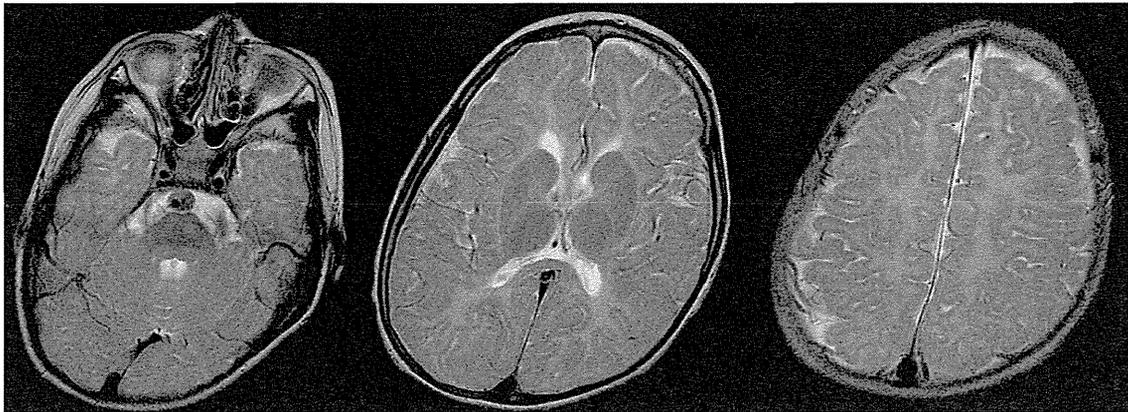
(Case 14, Type B). This patient was a 13-year-old male with *PLP1* duplication, and the clinical stage was F3. His symptoms started at birth with nystagmus, hypotonia, spasticity, and pyramidal signs. The first MRI was performed at 6 years old. The myelination age was 0–4 months on T1WI (A) and 4–8 months on T2WI (B). There was atrophy of the corpus callosum without cerebellar atrophy. Low signals in the posterior limb of internal capsules were identified on T2WI. This case manifested type B imaging. Note a couple of high signals in the pons on T2WI.
